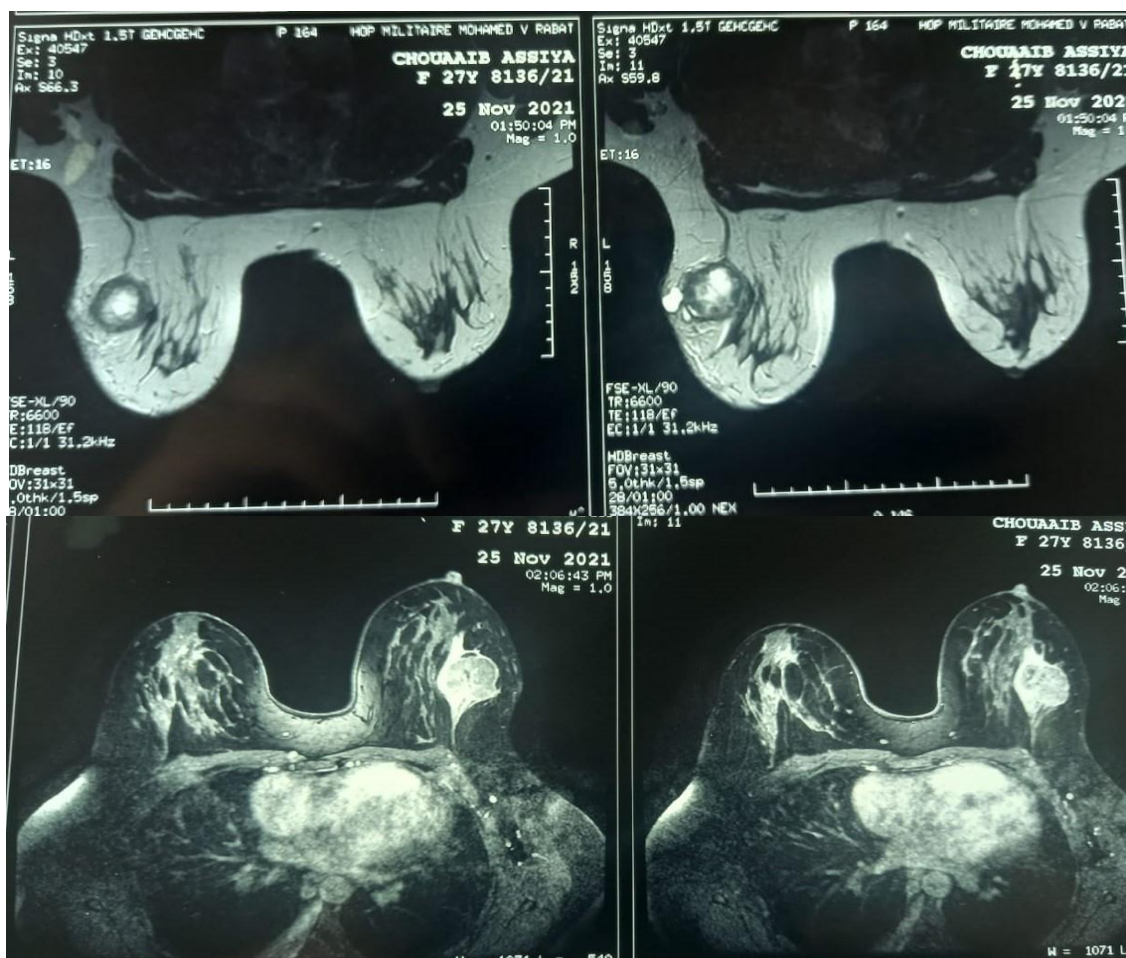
MRI aspect of a left breast mass at the level of the QSE at 5.5 cm from the nipple, bilobed hypointense T1, intermediate signal T2 measuring 33* 45*46 mm.
